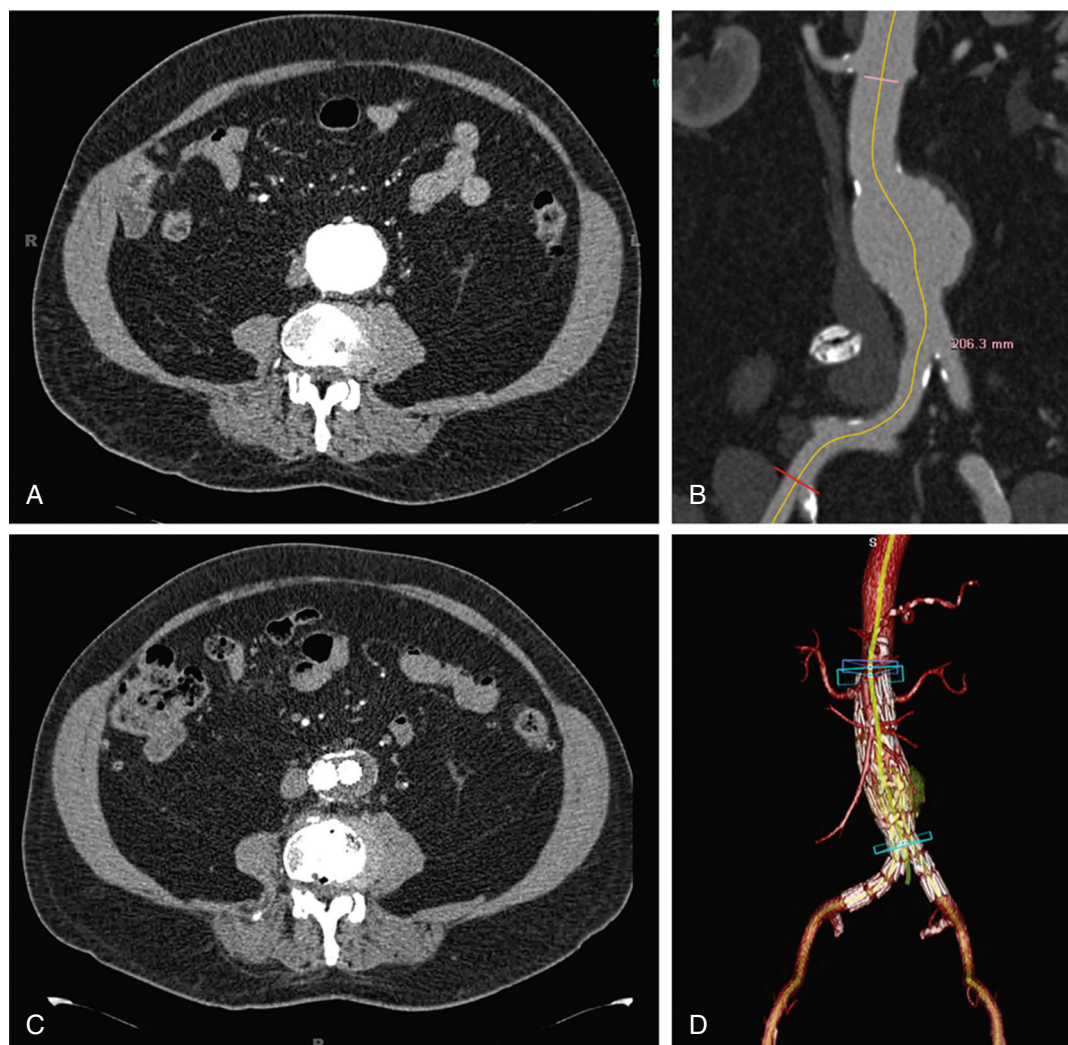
AAA before and after EVAR. A, CT axial image demonstrating a 5.3-cm infrarenal AAA. B, Preoperative CT scan with sagittal reconstructions demonstrating the 5.3-cm AAA and the anatomy of the aorta and iliac vessels. C, Postoperative cross-sectional CT images 1 year after EVAR demonstrating a decrease in AAA size and no endoleak. D, Postoperative three-dimensional reconstruction of the AAA 1 year after EVAR on the same patient. (Courtesy Dr. Gregorio Sicard, Washington University School of Medicine.)
